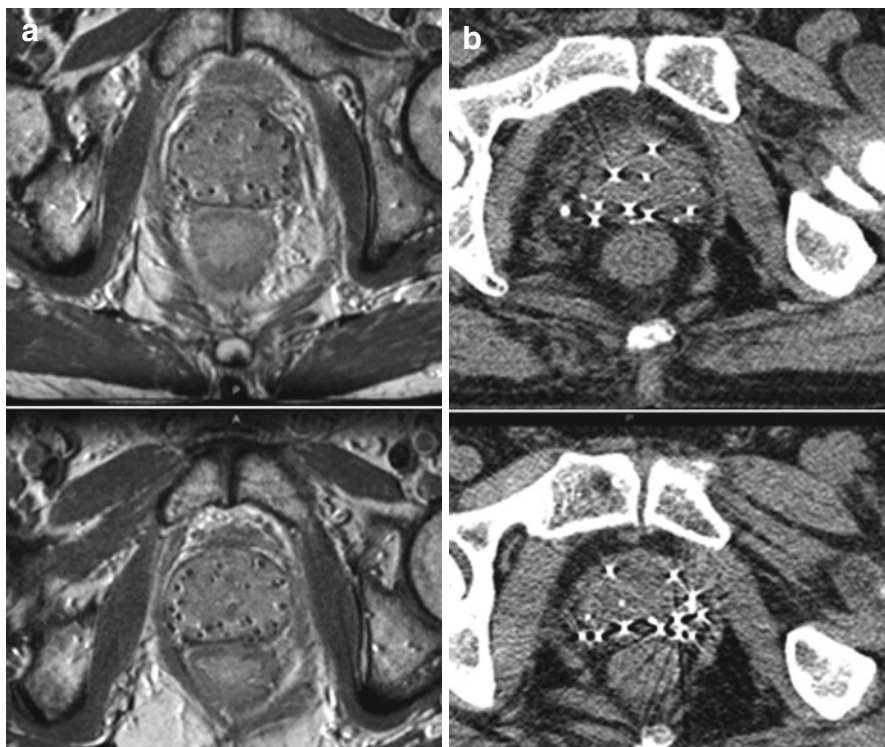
Axial CT (a) and MRI (b) on same patient scanned consecutively showing different appearances of rectum
